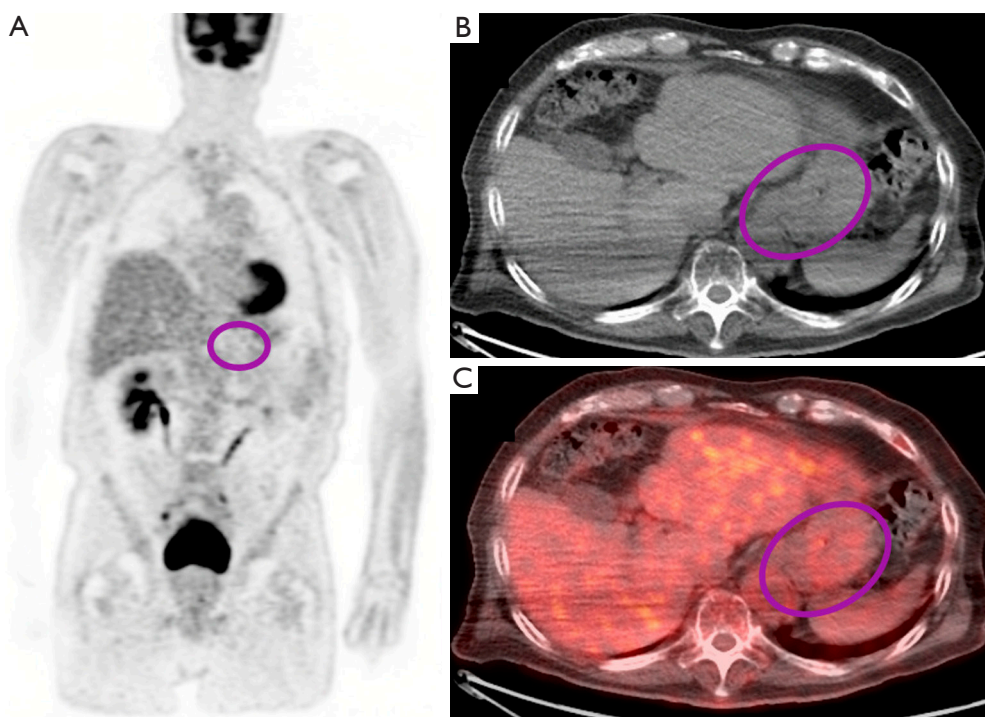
PET/CT imaging of non-detectable gastric malignancy after neoadjuvant immunotherapy. Coronal PET (A), Axial CT (B) and Axial Fused PET/CT (C) images demonstrate interval resolution of the previously noted hypermetabolic circumferential wall thickening involving the gastric cardia (circled).
